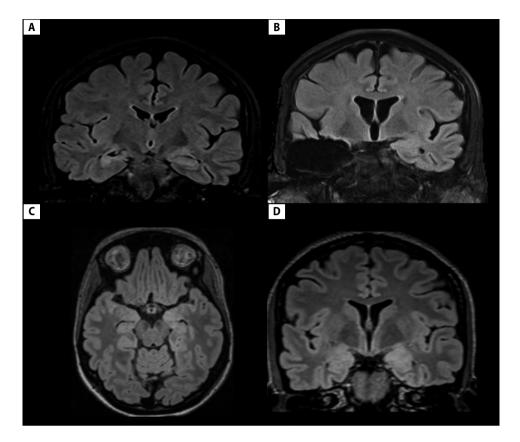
A (Case 4) – (2012) coronal T2W/FLAIR image shows increased signal intensity within right hippocampus, atrophy and disruption of internal structure of right hippocampus; B (Case 4) – (2015) follow-up MRI after right anterior temporal lobe resection, coronal T2W//FLAIR shows postoperative state on right side; C (Case 1) – (2020) larger left amygdala; left amygdala and left hippocampus with T2W/FLAIR hyperintensity and mild hippocampal atrophy; D (Case 1) – (2022) follow-up MRI after immunmodulatory treatment, axial T2W/FLAIR image displays slight decrease in amygdala volume with unchanged T2W/FLAIR hyperintensity, hippocampal appearance unchanged
